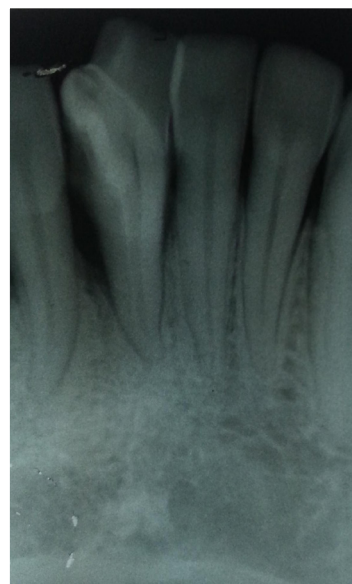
Intra oral periapical radiograph of geminated mandibular left incisor with the Talon's cusp
